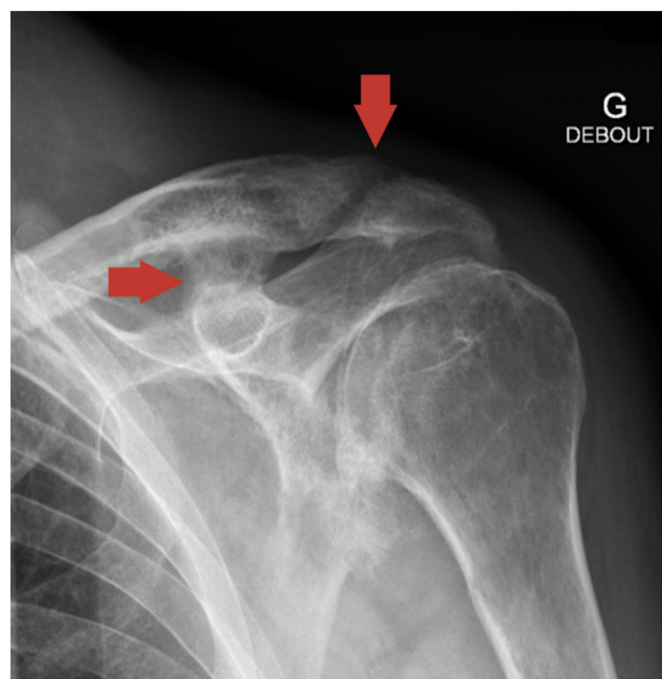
Preoperative anteroposterior shoulder radiograph demonstrating severe ankylosing glenohumeral arthritis and extensive ossification of the acromioclavicular and coracoclavicular ligaments (→).
